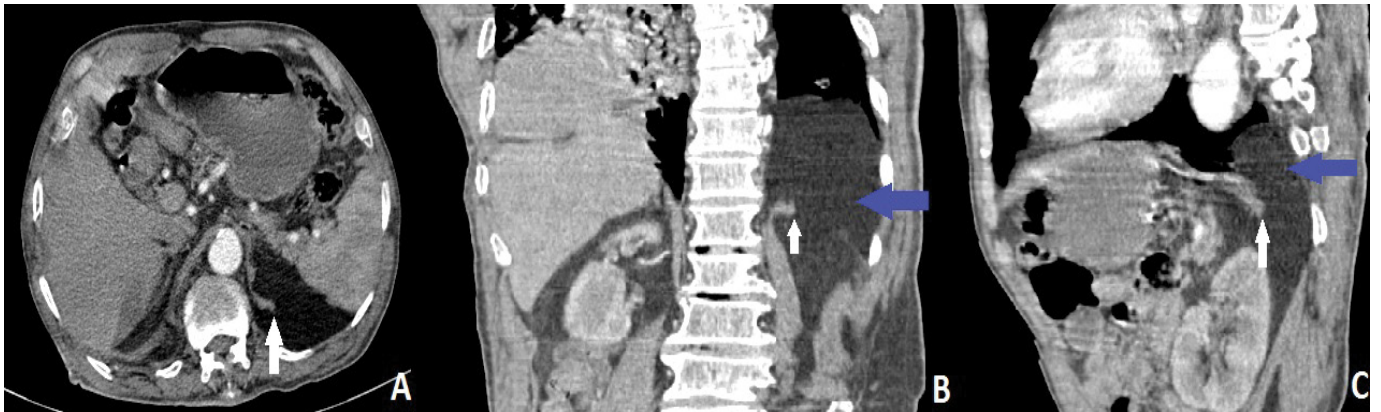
Axial (A) coronal (B) and sagittal views of an abdominal enhanced CT scan in arterial phase showing a large defect in the left dome of diaphragm (white arrow) with mental fat herniation into the thoracic cavity (blue arrow). The hernia orifice was located in the postero-lateral aspect of the left hemi-diaphragm which was in keeping with a late presenting Bochdalek type congenital diaphragmatic hernia.
